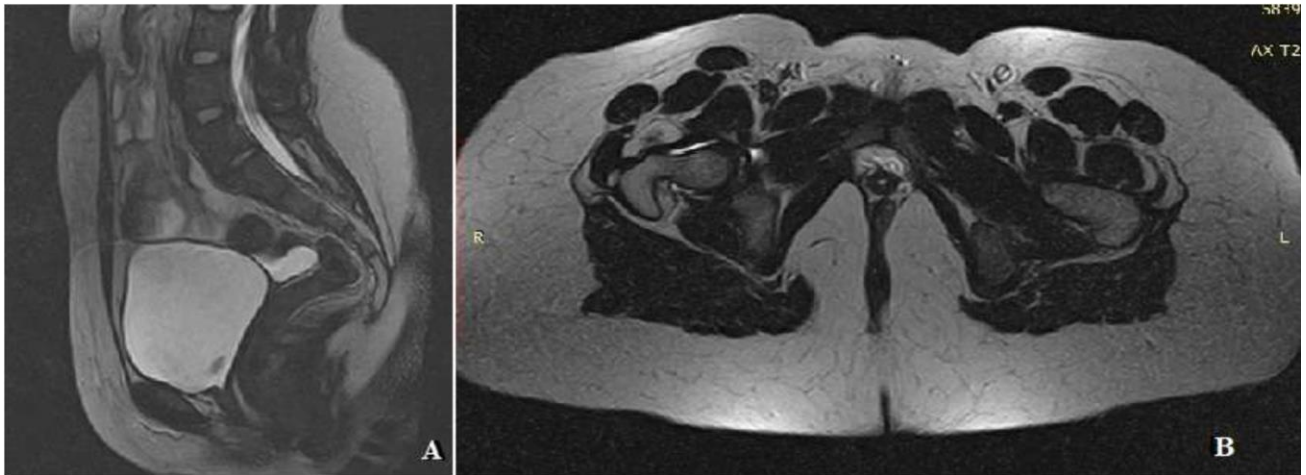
(A, B) Sagittal and axial T2-weighted MRI images from Case 1 showing agenesis of the uterus and upper vagina. A thin rim of nonspecific peritoneal fluid is also noted
